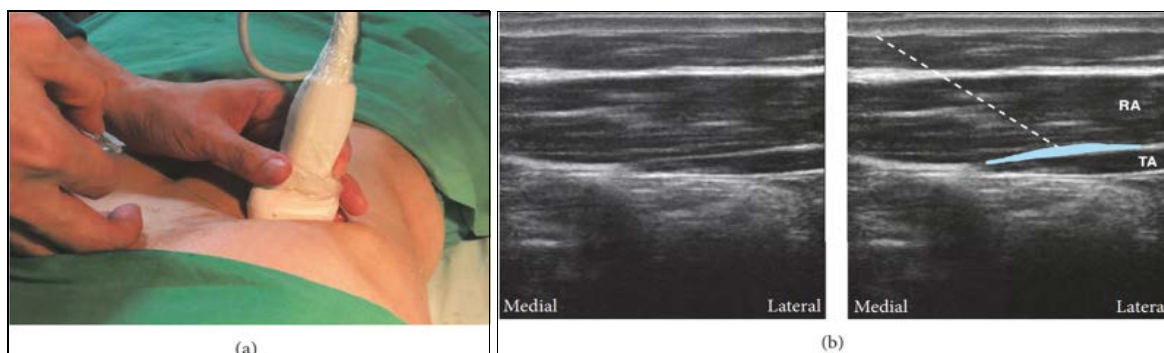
The transversus abdominis plane (TAP) block is performed using a subcostal technique. (a) The location of the probe and the direction of the needle. Near the xiphoid, the probe is positioned in a parallel fashion to the costal edge. It is put into the plane of the needle. (b) The ultrasound pictures that match to the condition. Local anaesthetic is placed in this plane to cover the upper TAP plexus, which is located between the rectus abdominis and the transversus abdominis. The TAP is located between these two muscles. The needle's path is shown by the dashed white line. A light blue area represents the locations where the local anaesthetic was deposited. RA stands for the rectus abdominis, while TA stands for the transversus abdominis. [11]
